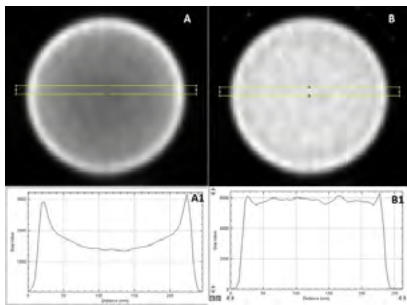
Profiles to check the accuracy of attenuation correction. A profile was drawn across one of the transverse slices. A and A1: no attenuation correction. B and B1: CT attenuation correction
